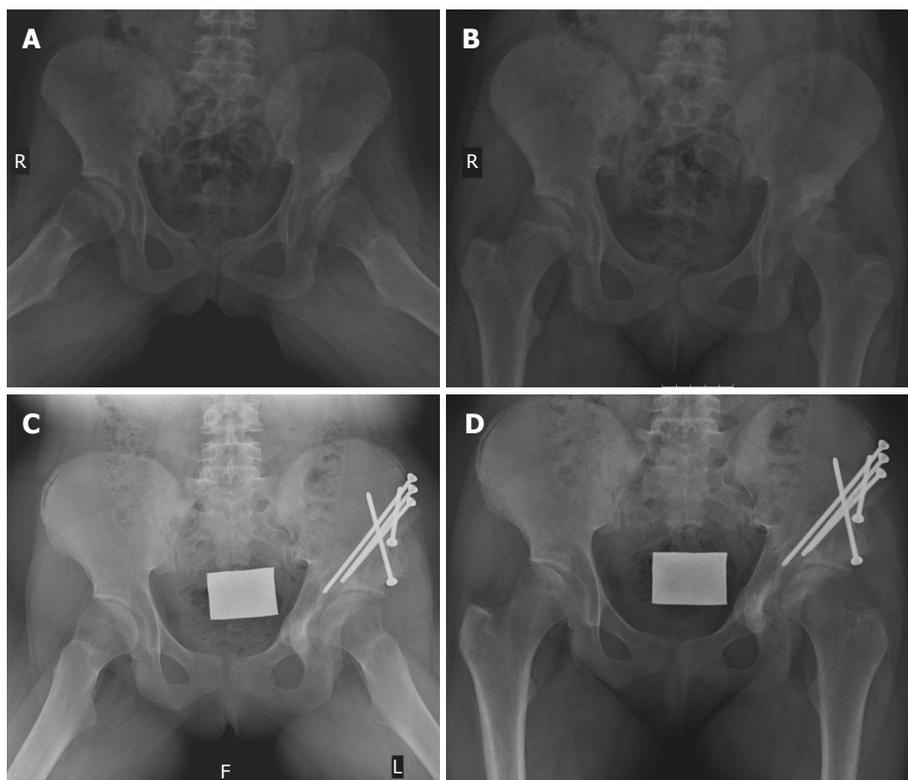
Female patient with developmental dysplasia of the hip that was diagnosed in early adolescence. A, B: X-rays at the time of diagnosis of DDH at the age of 13 years; C, D: X-rays taken two years after Ganz osteotomy on the left side. DDH: Developmental dysplasia of the hip.
